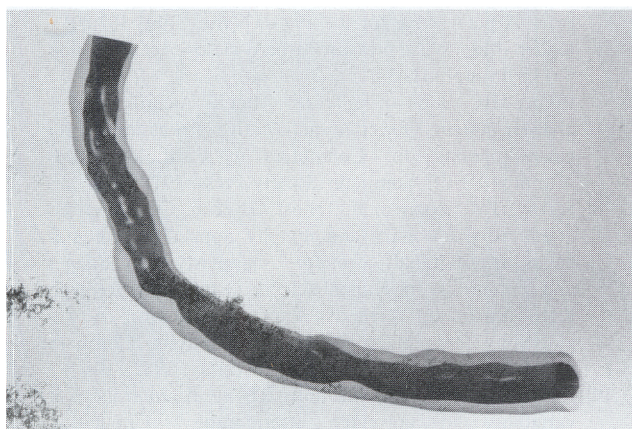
Combined use of biplane angiography and three-dimensional intracoronary ultrasound by ANGUS, a new method which allows the analysis of the true geometry of the vessel lumen and plaque, taking vessel curvatures and catheter bends into account [88]. A reconstruction of a diseased right coronary artery is displayed in a frontal projection. Ultrasound data provided by the contour detection method were spatially arranged and interpolated, using biplane data on both the pull-back trajectory and the angiogram.
